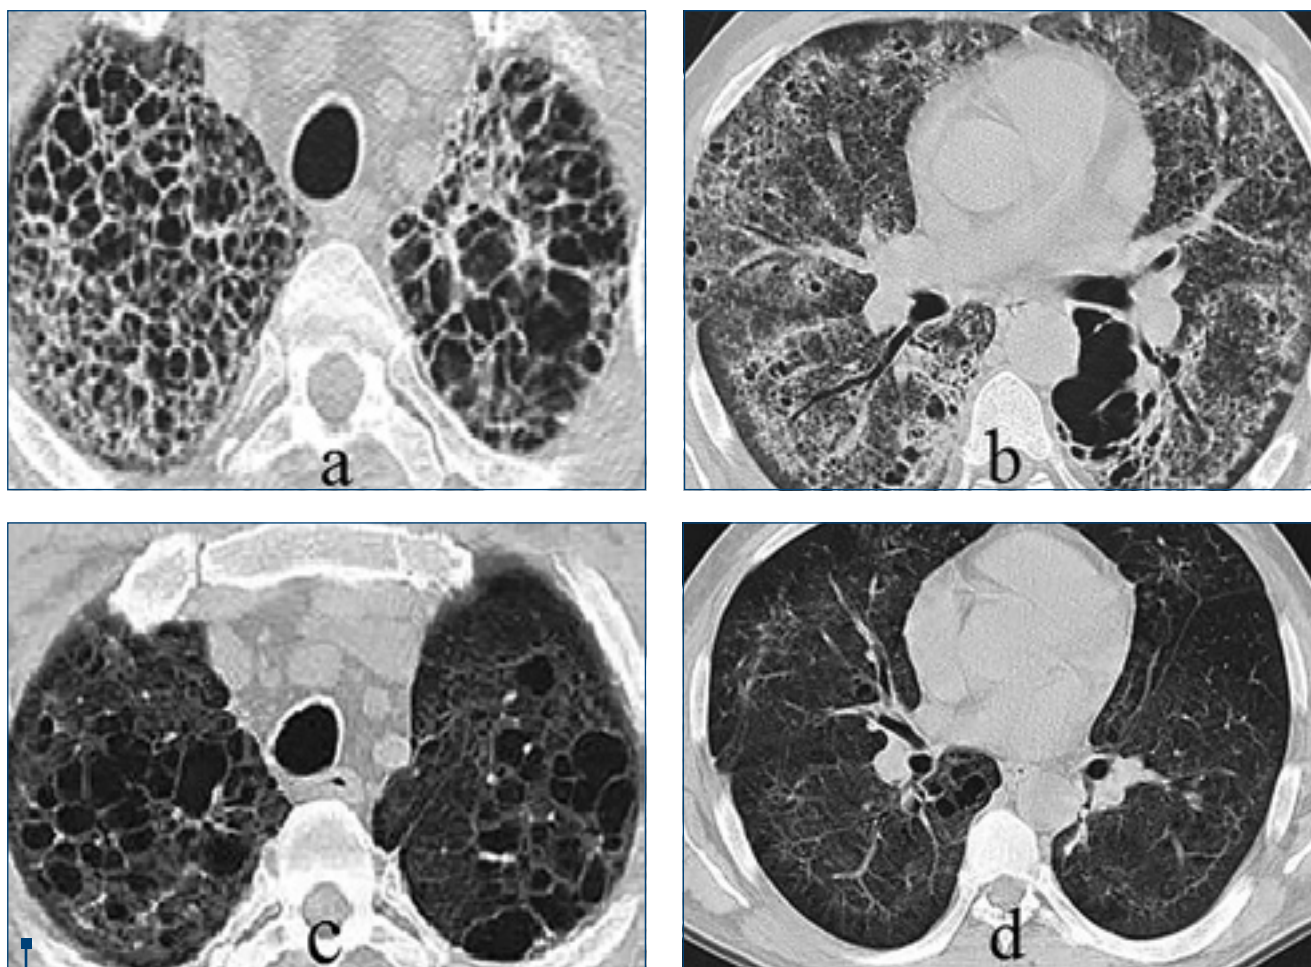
Chest CT-scan (a) Initially showing cystic lesions in the upper lobes, (b) ground-glass opacities, and honeycombing. (c) Follow-up with decreased number and area of cystic lesions in the upper lobes, and (d) disappearance of ground-glass opacities and decreased honeycombing in the mid and lower lobes.
